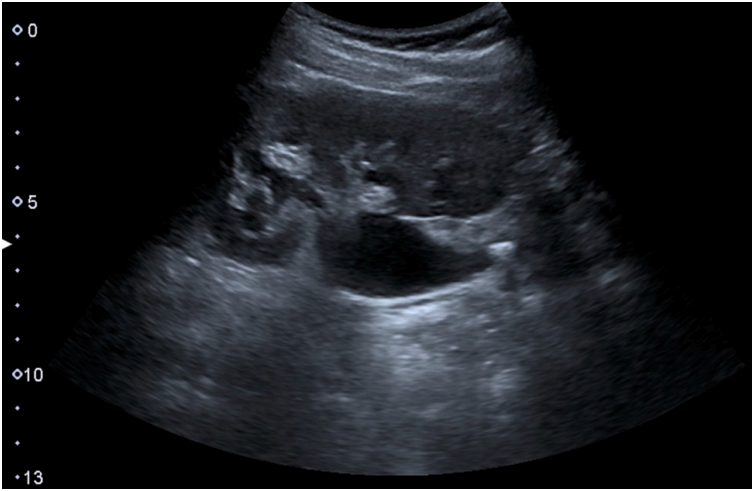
Ultrasound scan of renal stone located at the pyeloureteral junction. [Renal stone located at the pyeloureteric junction with accompanying hydronephrosis](#) by Hansen KL, Nielsen MB, Ewertsen C licensed under [CC BY 4.0](#)
